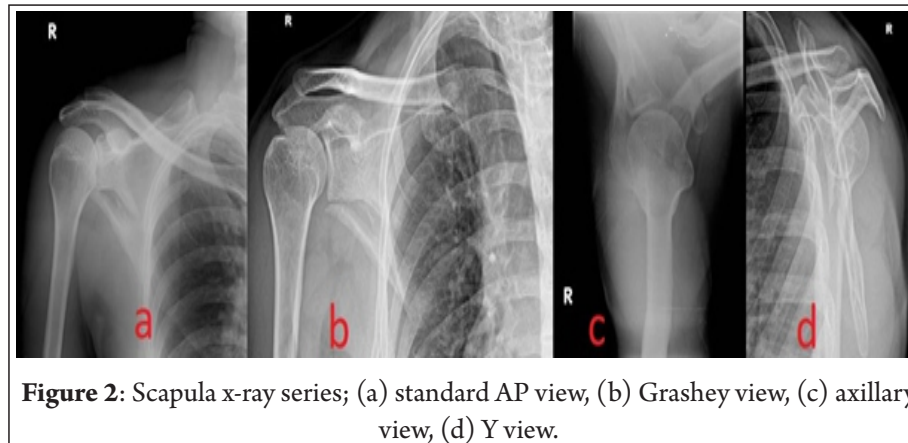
Scapula x-ray series; (a) standard AP view, (b) Grashey view, (c) axillary view, (d) Y view.
